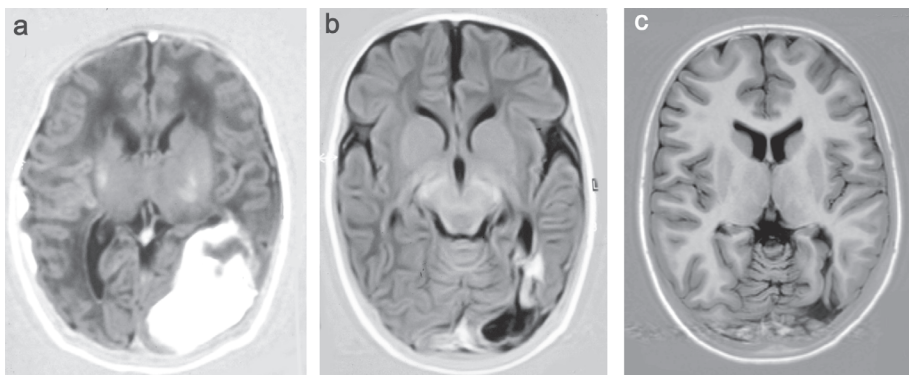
MRI and IR axial view obtained on day 8, at 3 months, and at 11 years. A large parieto-occipital hemorrhage is seen in the neonatal period (a). The hemorrhage has almost completely resolved by 3 months, resulting in a small cavity (b), which is still present at 11 years (c). Outcome is within the normal range.
